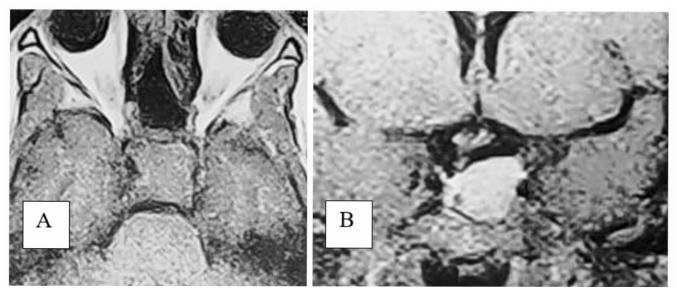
Preoperative axial (A) and coronal (B) MRI T1WI showing a pituitary macroadenoma.
